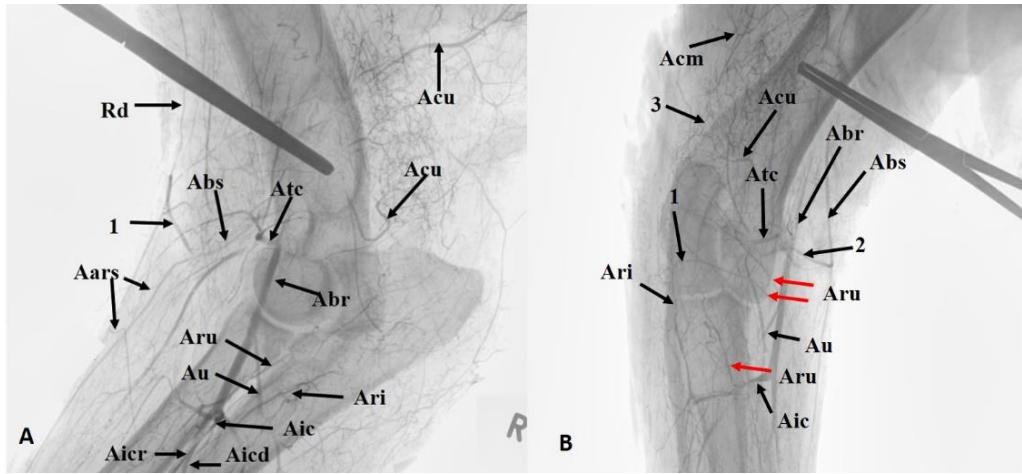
A Postmortem radiography in mediolateral view - Abr – a. brachialis, Rd – r. deltoideus, Aars – aa. radiales superficiales, Acu – a. collateralis ulnaris, Abs – a. brachialis superficialis, Atc – a. transversa cubiti, Aru – a. recurrens ulnaris, Au – a. ulnaris, Ari – a. recurrens interossea, Aic – a. interossea communis, Aicr – a. interossea cranialis, Aicd – a. interossea caudalis, 1 – connection between r. deltoideus and a. brachialis superficialis; B Postmortem radiography in craniocaudal view Acm – a. collateralis media, Abs – a. brachialis superficialis, Atc – a. transversa cubiti, Acu – a. collateralis ulnaris, Aru – a. recurrens ulnaris, Au – a. ulnaris, Ari – a. recurrens interossea, Aic – a. interossea communis, 1 – connection between a. recurrens ulnaris and a. recurrens interossea, 2 - connection between a. brachialis superficialis and a. recurrens ulnaris, 3 – connection between a. collateralis media and a. collateralis ulnaris.
